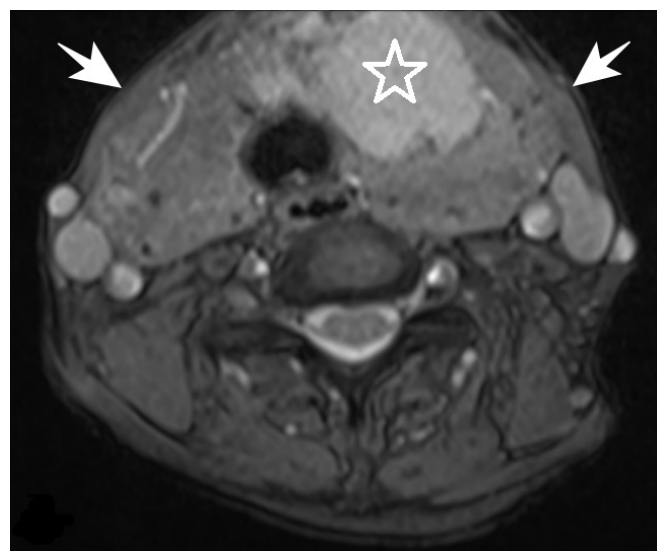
Axial T2-weighted image shows thyroid gland enlargement consistent with goiter (arrows) and a well-circumscribed thyroid nodule (star).
